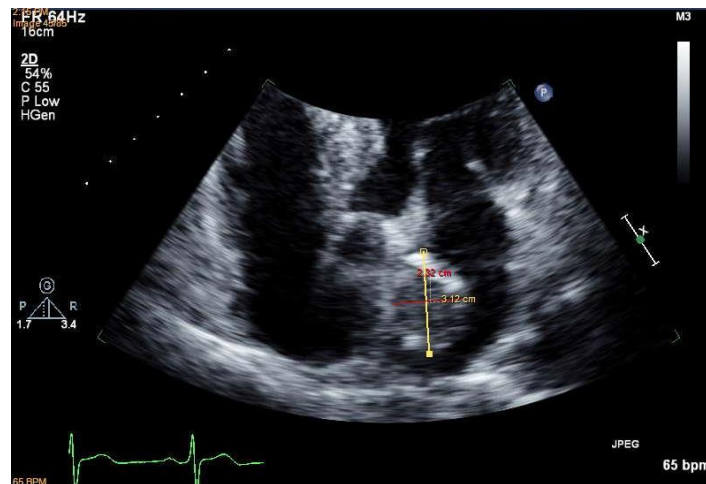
Preoperative echocardiography. The tumor was approximately 3×2 cm in size with no stalk.
